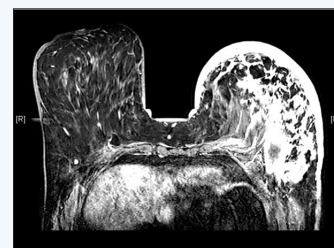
An MRI showed a large left mass infiltrating the whole breast and skin.
